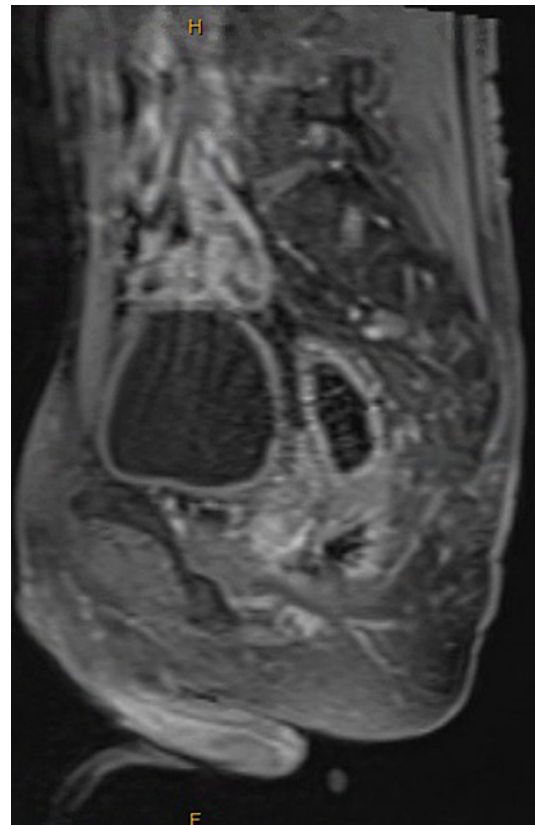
Sagittal view of tumor. Lowest extent of the tumor has 10.7 cm distance from the anal verge and 6.3 cm distance from the top of the anal sphincter. Remainder of patient's MRI showed no signs of suspicious lymph nodes, extramural vascular or mesorectal fat invasion, or distant metastases.
